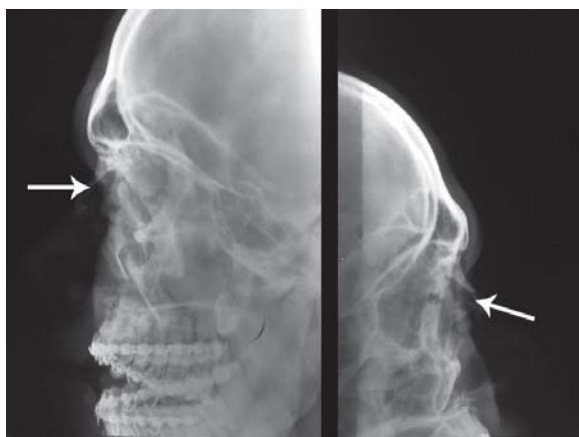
X-ray facial skeleton lateral view showing fracture nasal bone
